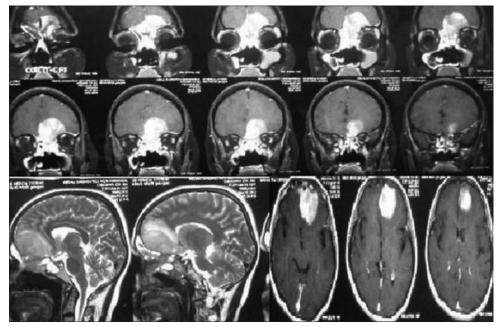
Magnetic resonance imaging brain showing intensely enhancing lesion of the ethmoids invading brain via the cribriform plates
